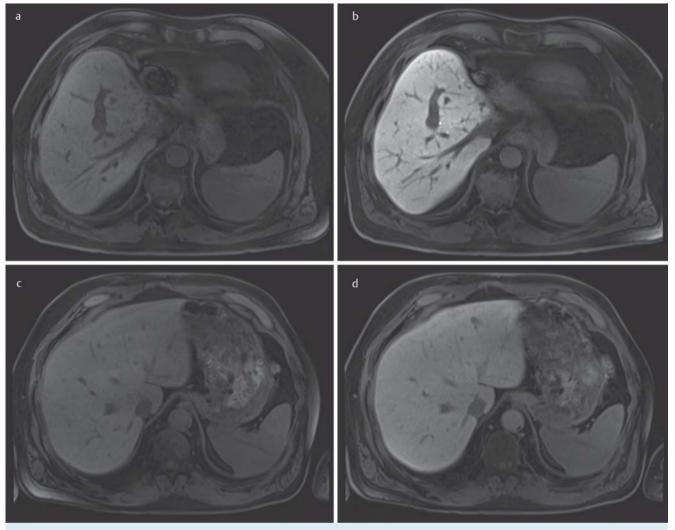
T1-weighted VIBE sequence with fat suppression of the unenhanced phase a, c and the hepatobiliary phase b, d after 20 minutes. a, b show sequences of a male patient with a weight of 104 kg and a height of 1.89 m. The calculated liver volume was 2117 ml, with the actual liver volume being only 1625 ml. This yielded a Δ liver volume of -492 ml. c, d show
